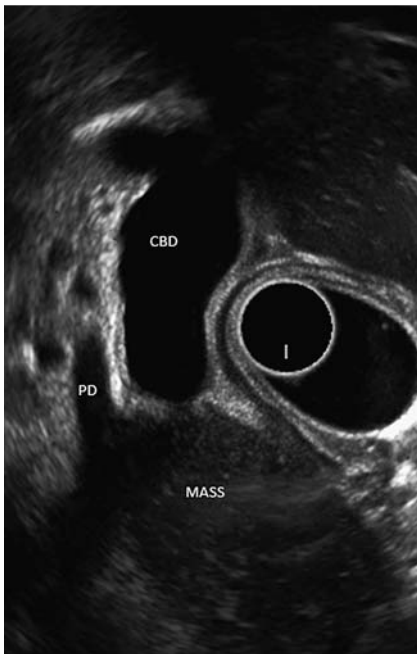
Endoscopic ultrasound: lesion obstructing the common bile duct (CBD) as well as the pancreatic duct (PD).
